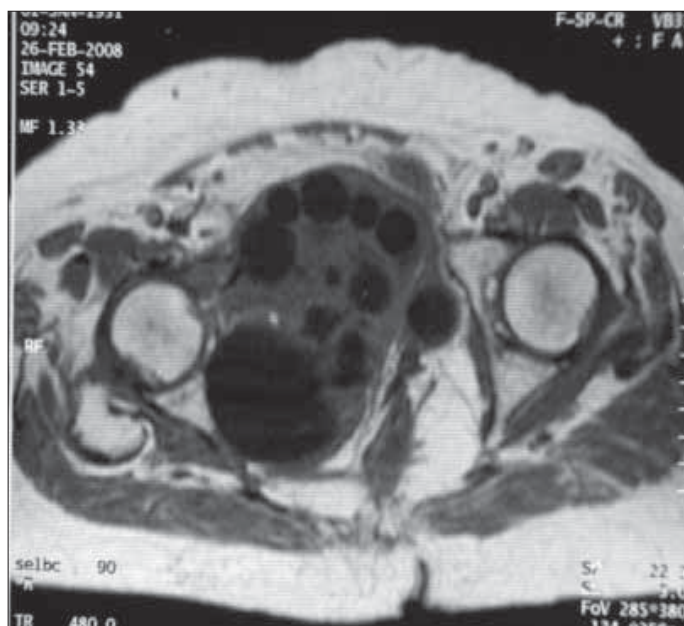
Sagittal MRI demonstrates lesion with solid and cystic components
